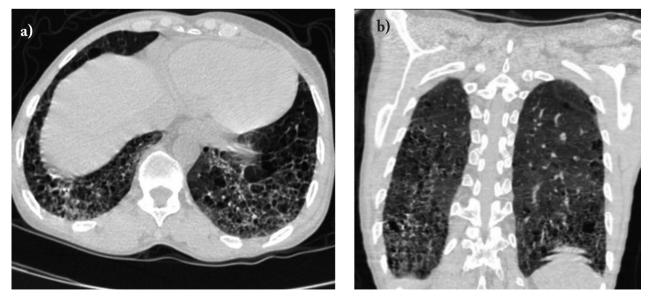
Axial (a) and coronal (b) CT images show extensive interstitial thickening and multiple cystic changes giving the lung parenchyma a honeycomb appearance
